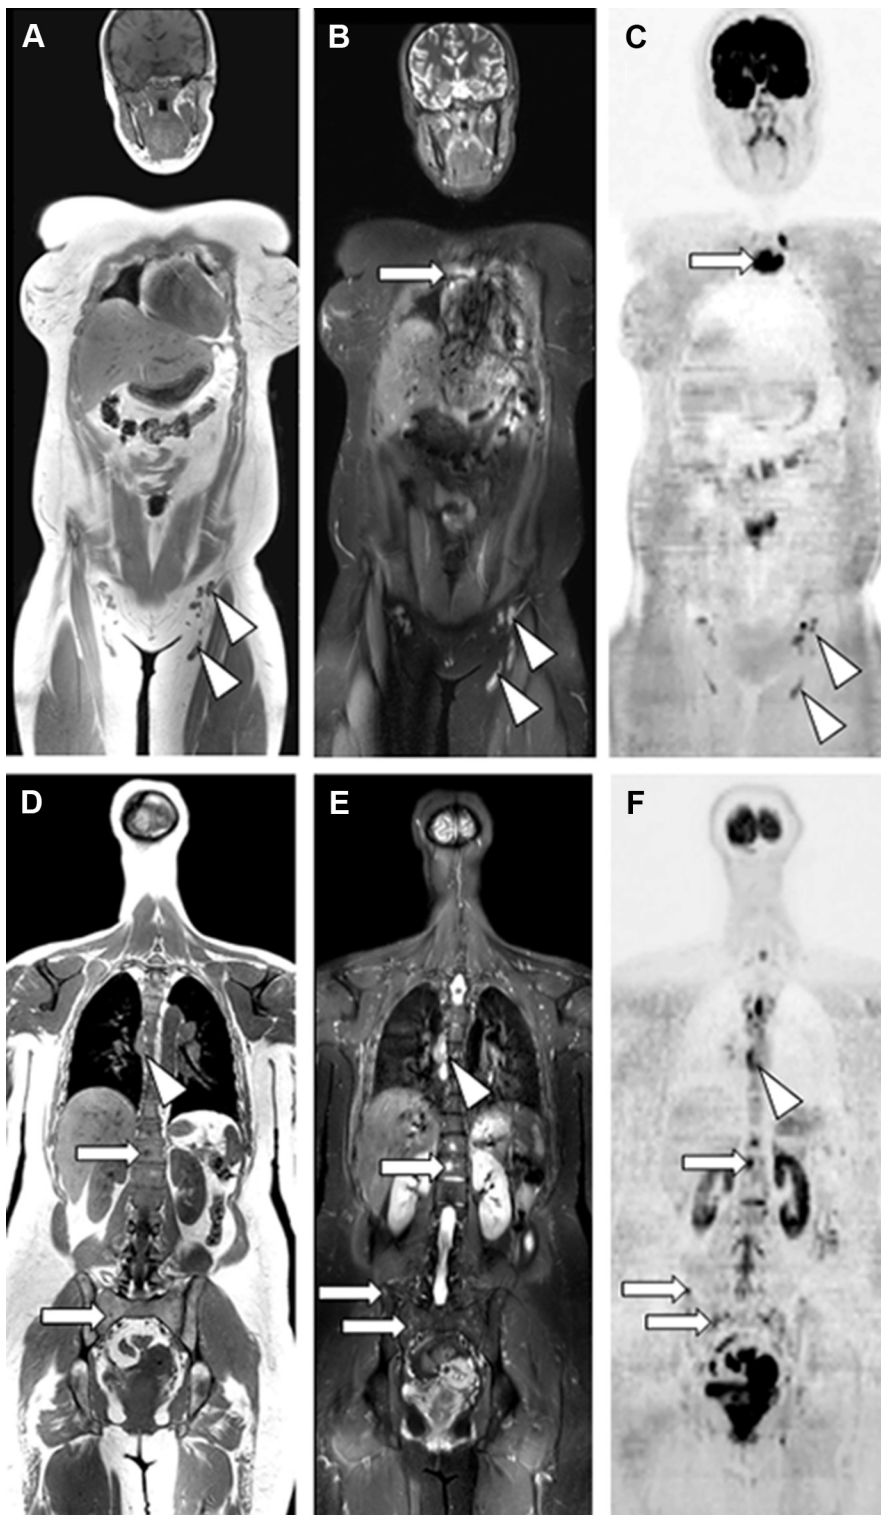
WB MR imaging from a 34-year-old woman presenting with sarcoidosis. Anterior coronal T1 (A), STIR (B), and diffusion-weighted (C) MR imaging shows bone lesion (arrows) in the manubrium sterni, and inguinal lymphadenopathies (arrowheads). More posterior coronal slices (D–F) show bone lesion (arrows) in the spine and pelvis, and mediastinal lymphadenopathies (arrowheads). The coexistence of lymphadenopathies involving the mediastinum and inguinal areas is suggestive of sarcoidosis, although other malignant conditions, especially lymphoma, should be ruled out.
